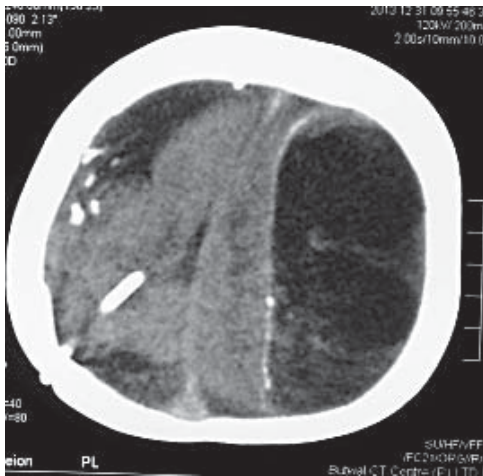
CT scan showing the shunt tip in situ and the ventricles were slit-like
